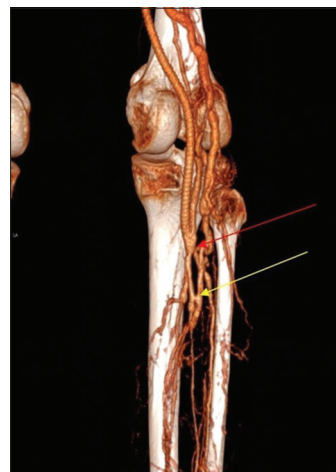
Multislice computed tomography angiography after femoropopliteal bypass- multiple Arteriovenous fistulas in the right lower leg (red arrow shows the communication between anterior tibial artery and its vein; yellow arrow shows the communication between tibioperoneal trunk and vein)
